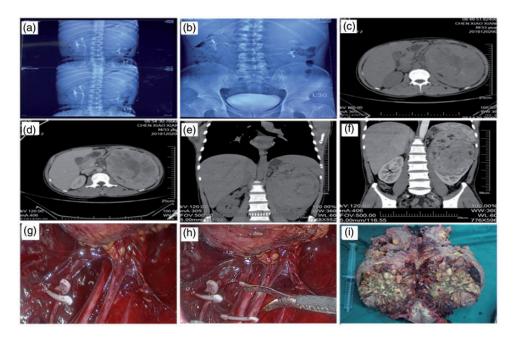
(a and b) Intravenous pyelography examination revealing duplex kidney. (c) Computed tomography scan revealing a large mass with mixed density in the upper pole of the left kidney with a clear boundary. (d) Three-phase enhanced computed tomography scan showing obviously uneven enhancement in the necrotic liquefied area. (e) Coronal plain computed tomography scan. (f) Coronal enhanced computed tomography scan. (g) Finding of a double ureter during the operation. (h) Laparoscopic radical resection of the kidney tumor. (i) The large mass following radical nephrectomy.
